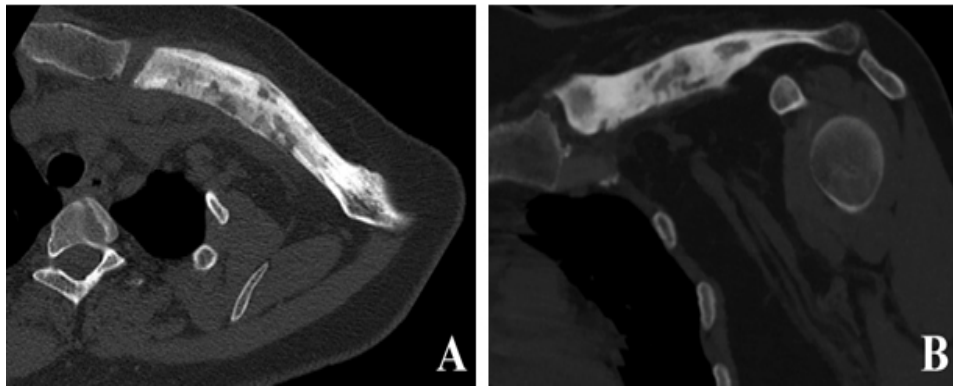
Axial (A) and coronal (B) computed tomography of left clavicle showing hypertrophy with areas of osteocondensation and heterogeneous lacunar zones.
